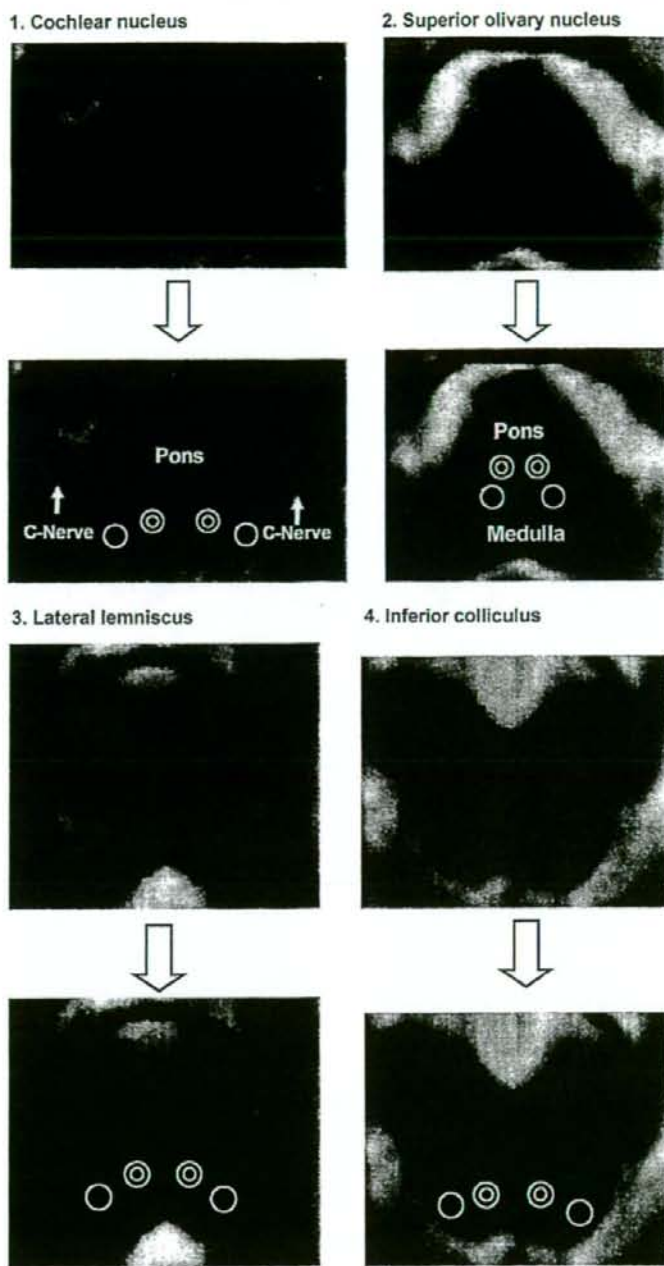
Depiction of regions of interest (T2-weighted images). A circle is placed at each point of the brainstem auditory nuclei and pathway (cochlear nucleus, superior olivary nucleus, lateral lemniscus, and inferior colliculus) and a double circle is placed at the surrounding gray or white matter. (1) Cochlear nucleus (circle); an arrow indicates cochlear nerves (C-Nerve). (2) Superior olivary nucleus (circle); the pons and medulla are shown. (3) Lateral lemniscus (circle). (4) Inferior colliculus (circle).
